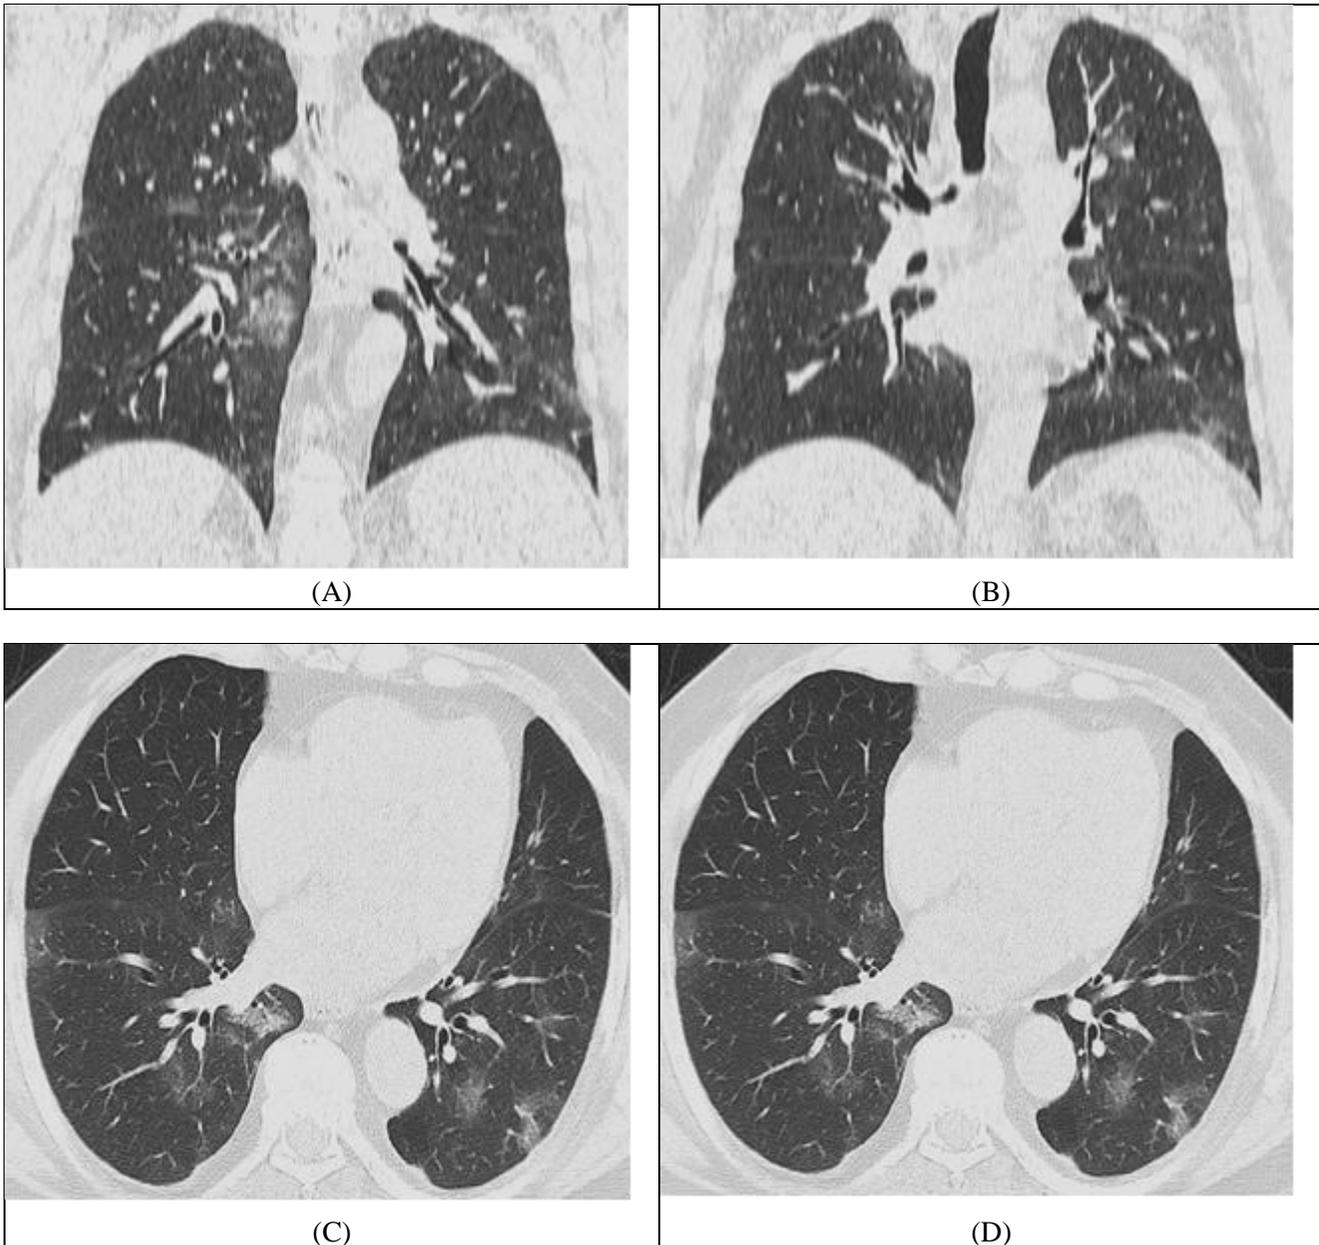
(A-D) CT coronal reformatted images (A, B) and axial images (C, D) demonstrating multiple bilateral regions of ground glass densities, which are seen involving different lung lobes, they are mixed peripheral (arrow in image C) and peribronchovascular (arrow in image D) nodules.
